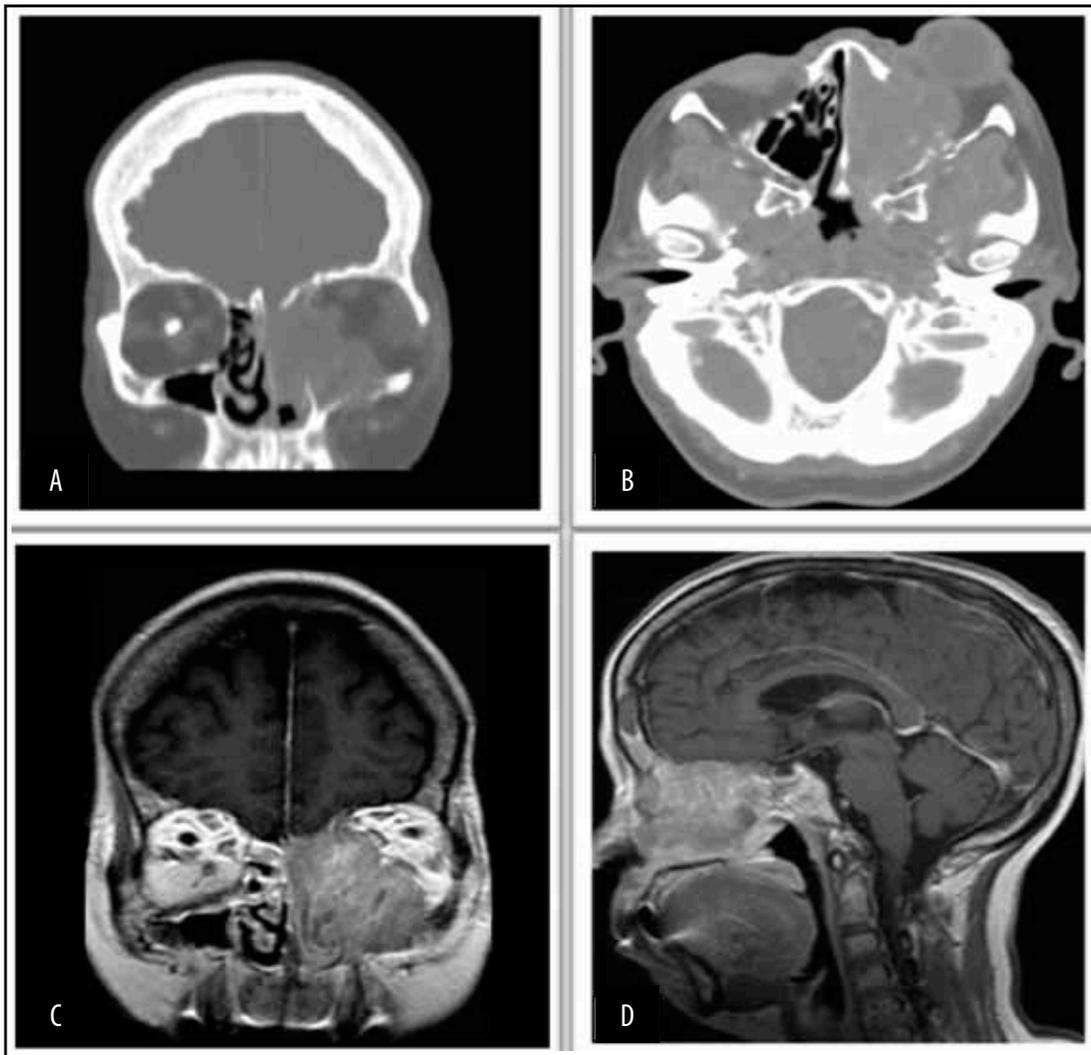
Cranio-facial CT scan (coronal (A) and axial (B) sections) and brain MRI (coronal (C) and sagittal (D) slices) – tumor mass located in the left maxillary sinus with extension to the left orbit (producing osteolysis of the inferior and medial orbital walls), nasopharynx, ethmoidal cells and left frontal sinus.
